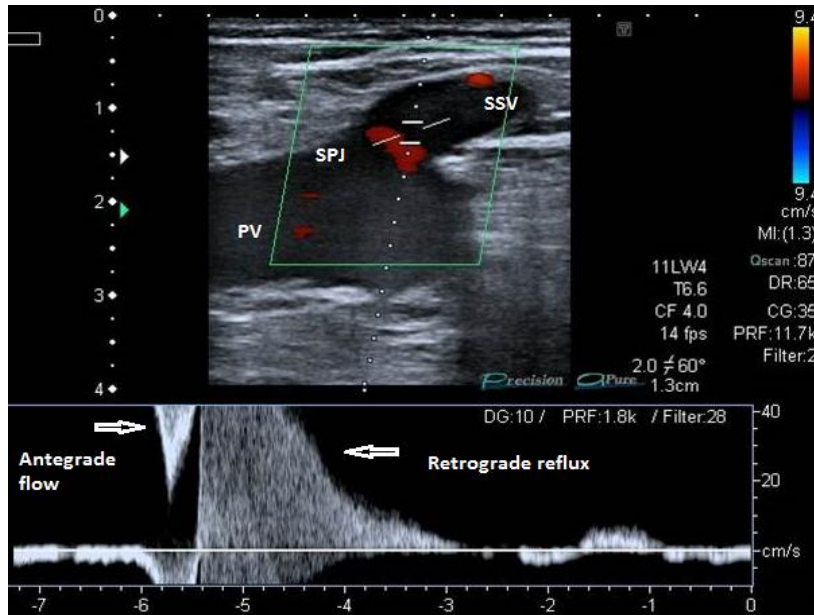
Spectral Doppler demonstrating SPJ incompetence with reflux into SSV in longitudinal section
